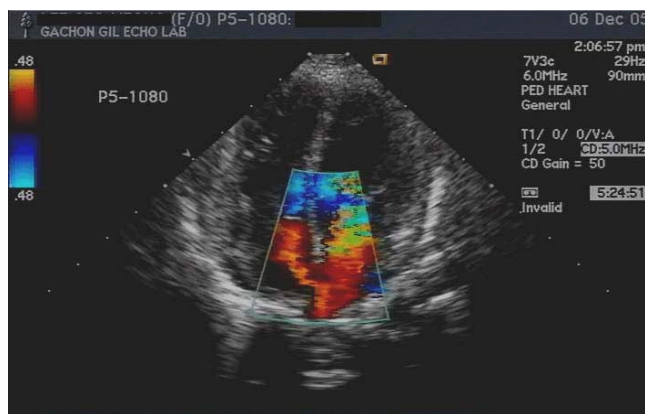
Echocardiography (apical 4 chamber view) shows atrial septal defect.
